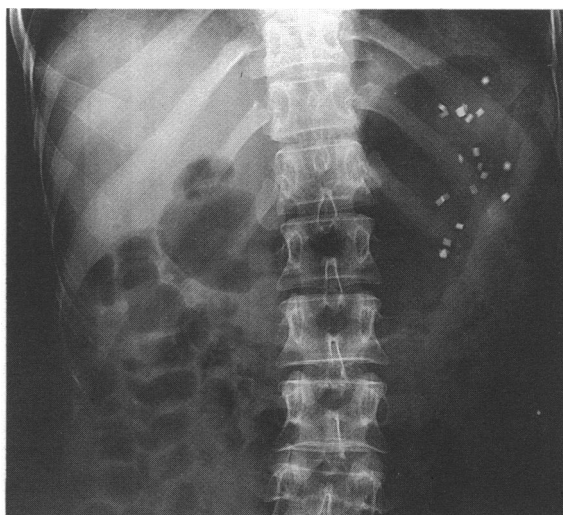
Plain abdominal X-ray of a control patient showing radio-opaque pellets all lying within the gastric shadow
